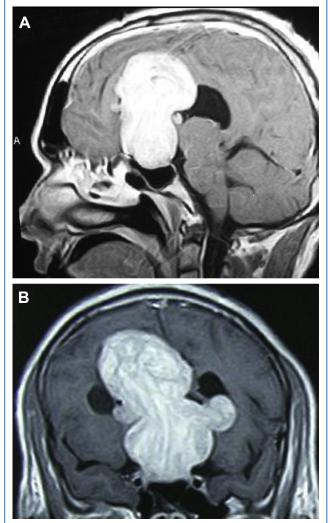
(A) Contrast-enhanced sagittal image of magnetic resonance imaging shows a grade I pituitary tumor. The diaphragma sellae is elevated by the giant tumor. (B) Coronal image of the tumor. The dome of the tumor has lobulated the diaphragma sellae but has not transgressed it.
